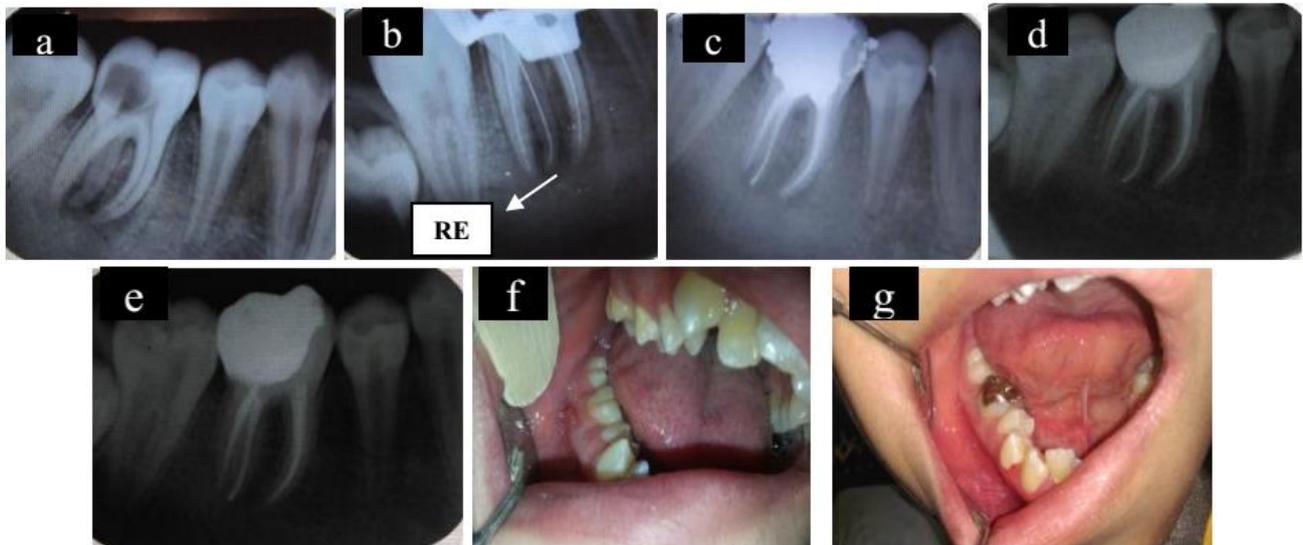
a) Preoperative radiograph. b) Determination of working lengths by radiography. c) Post obturation radiograph. d) Three-month follow-up. e) six- month follow-up f, g) before and after treatment.
